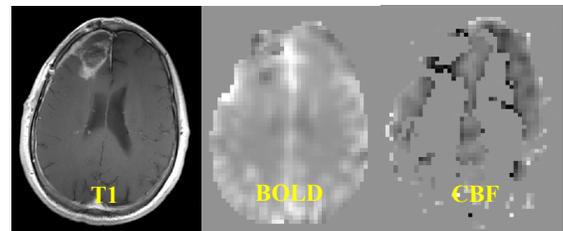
a) top: post-Gd T1-weighted, and relative BOLD and CBF maps for a representative GBM patient b) bottom: graphs for signal changes in BOLD (red) and in CBF (blue)
